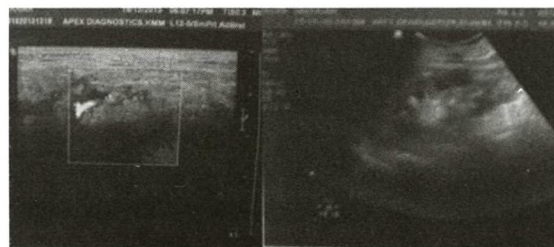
Ultrasonographic image of the sialolith in the submandibular duct.
